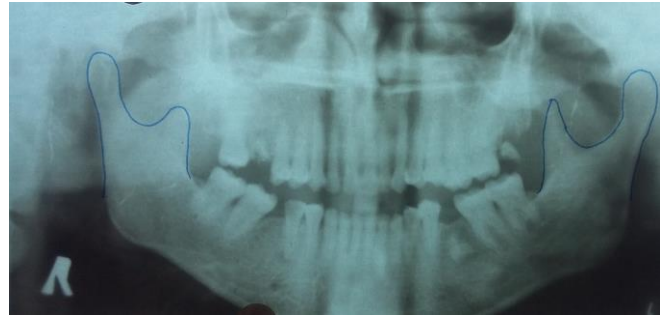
Orthopantomogram showing angled condylar process on right with sloping sigmoid notch
